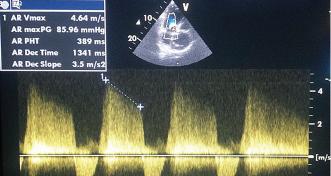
Quantification of aortic regurgitation using continuous wave Doppler.
